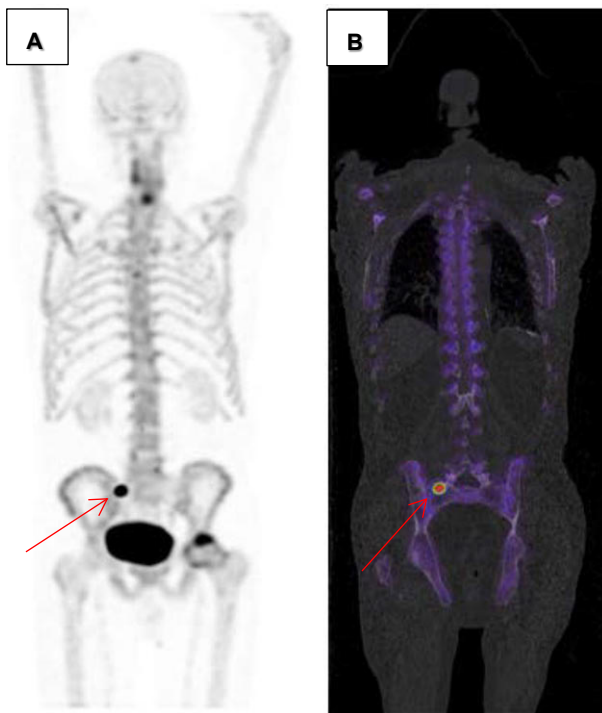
A case example of standard imaging modalities in primary metastasis staging of PCa. Images of the planar bone scintigraphy (BS) (A) and thorax and abdominopelvic coronal CT with (B) and without contrast (C) from a study patient. Note the red arrows pointing to the lesion suspicious for PCa bone metastasis in the sacrum with radiotracer uptake on BS (A) and sclerosis on CT (C).
